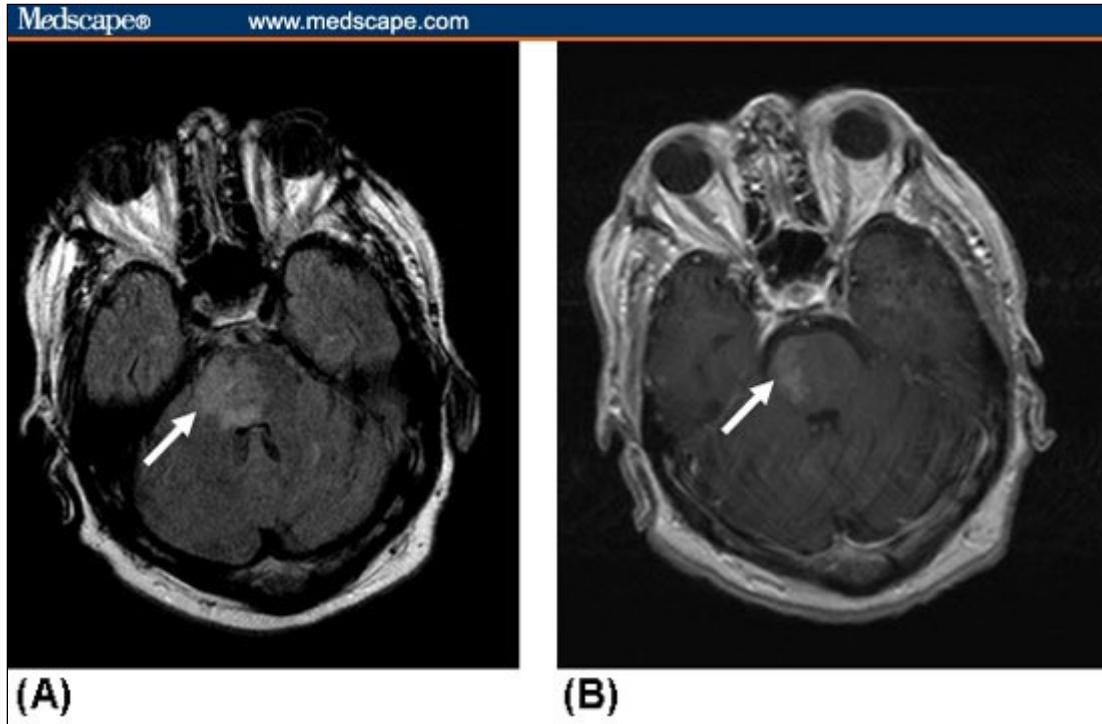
MRI images depicting primary CNS lymphoma. (A) FLAIR and (B) postgadolinium images demonstrated an enhancing infiltrative lesion in the mid pons. Spinal fluid cytology was positive for malignant lymphocytes.
